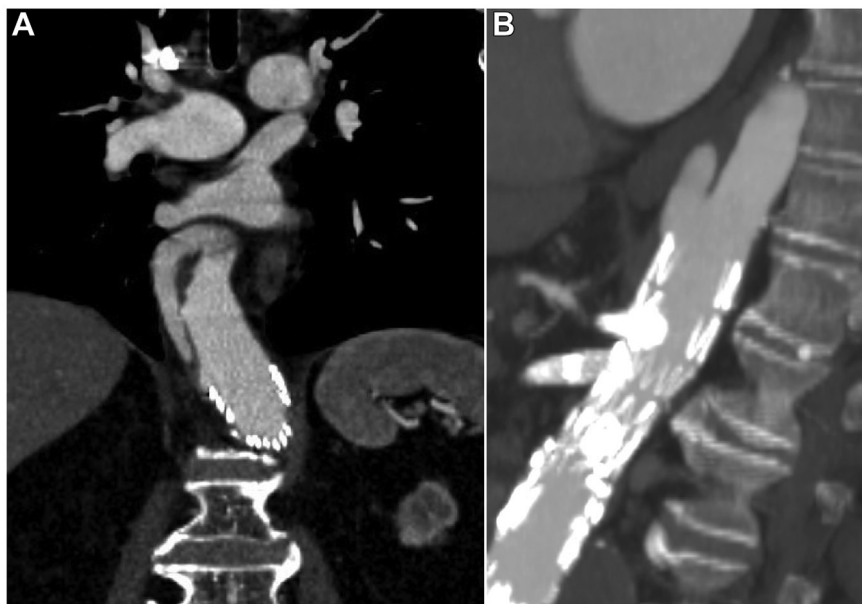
Coronal (A) and sagittal (B) views of a computed tomography scan 4 months after fenestrated endovascular abdominal aortic aneurysm repair (FEVAR) demonstrating acute type B aortic dissection (TBAD) originating from top of previously placed endograft.
